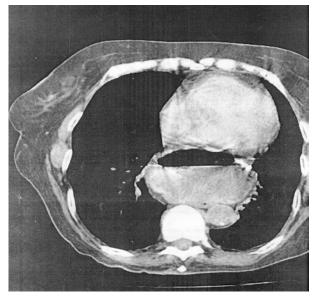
CT scan : Hiatus hernia
